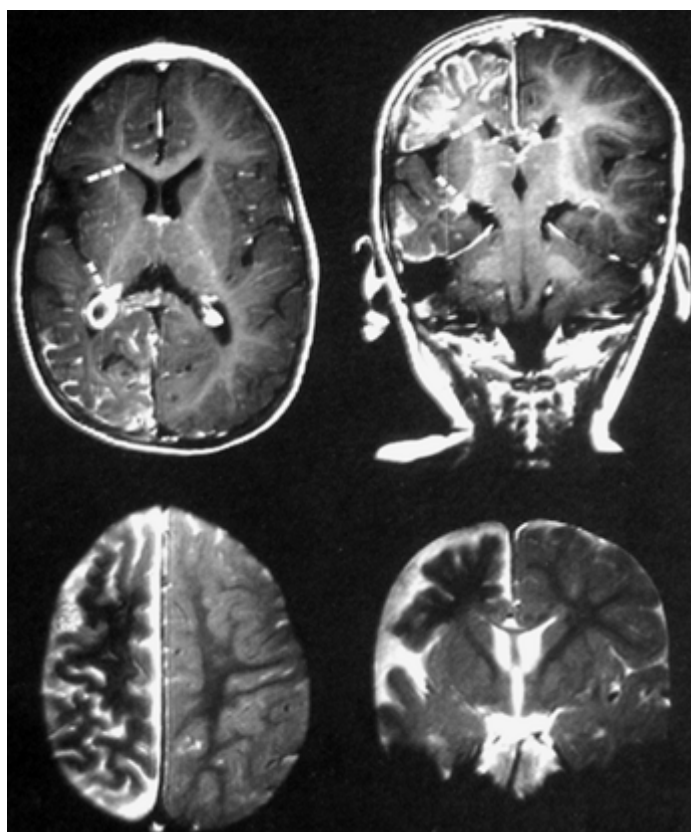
Sturge-Weber disease in a 16-month-old male. Axial (left) and coronal (right) magnetic resonance images with contrast (upper) show the pathologic vascularization and the enlarged insular cistern and atrophy of single gyri and the whole hemisphere. White lines indicate the short distances between circular sulcus and ventricle. This case was done with the transsylvian keyhole functional hemispherectomy technique. (Reproduced from Schramm J. Hemispherectomy techniques. *Neurosurg Clin N Am.* 2002;13[1]:113-134, with permission.)
